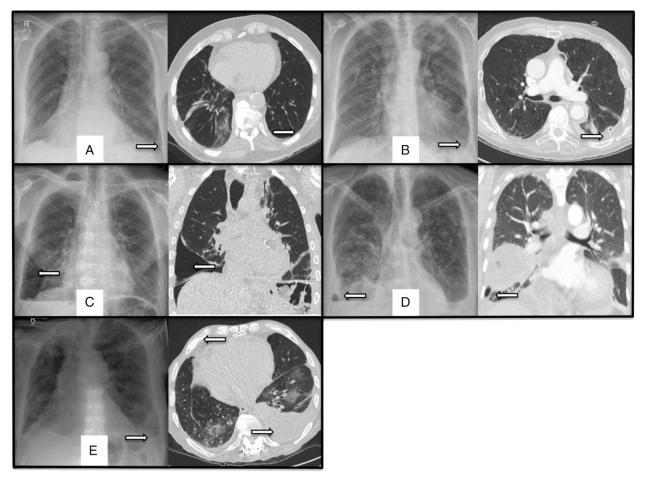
Entrapped lung scoring by radiograph (left images in each panel) and CT scan (right images in each panel). A, Definitely free. Complete apposition of parietal and visceral pleura (arrows). B, Probably free. Apposition of parietal and visceral pleura in most places but some residual pleural fluid (arrows). C, Definitely entrapped. Air separating the visceral and parietal pleura around the lower lobe (arrows) (a chest tube is also seen within the pleural space). D, Probably entrapped. Some air between visceral and parietal pleura in places around the lower lobe but residual pleural fluid obscuring some areas (arrows). E, Unable to score. Insufficient drainage of pleural fluid to allow designation in one of the prior categories (arrows).
